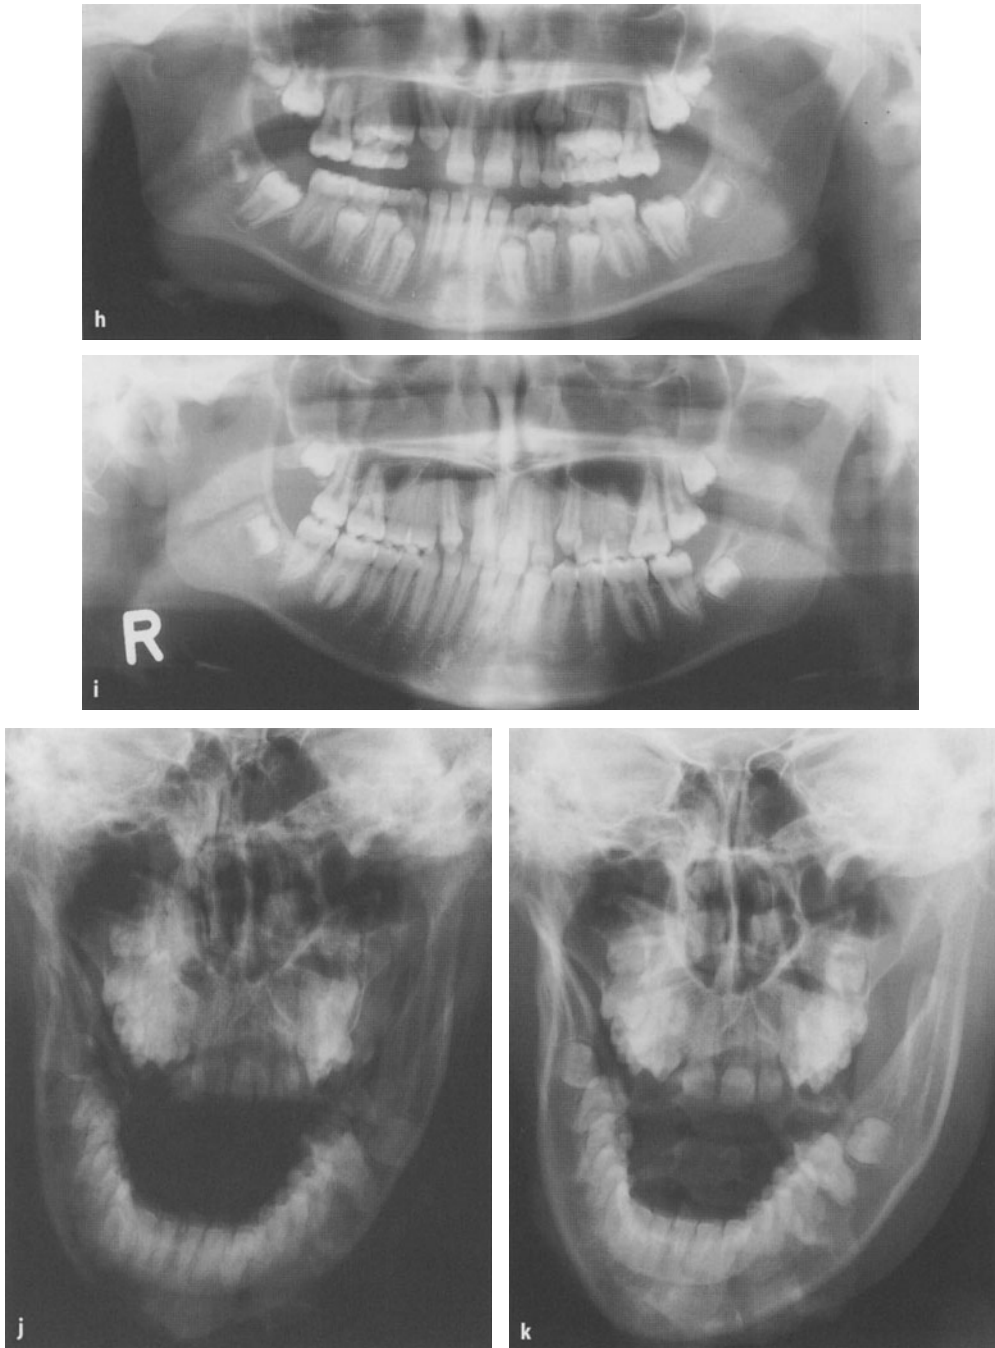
Unilateral active hybrid form with H.E. predominance and contralateral hemimandibular hypoplasia. h The panoramic radiograph, taken at 11 years and 8 months, showing a long left side with a longer and thicker neck than normal and a rather small condyle and a short right ascending ramus with a short neck and a slightly deformed condyle. i The panoramic view, taken 2 years later (age 13 years and 8 months) reveals a further increase in the difference between the two hemimandibles. j, k The p.a. projection of the mandible at maximum opening, taken at 11 years and 8 months, shows a much longer left mandible than the right and the same projection, taken 2 years later, leaves no doubt that there is further rapid overgrowth of the left side
